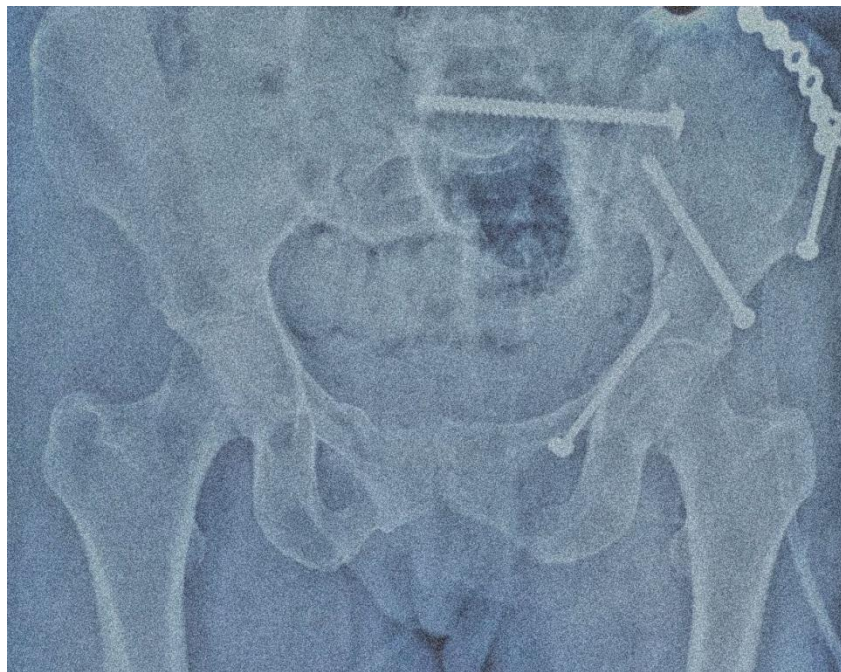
7-month follow-up X-ray PBHS.
